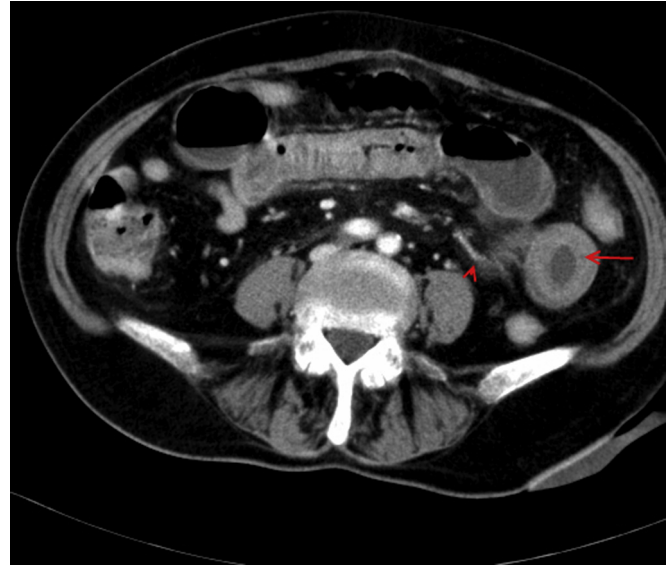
Abdominal computed tomography demonstrating patency of mesentery vessels (arrowhead) and segmental intramural hematoma affecting distal jejunum (arrow).
